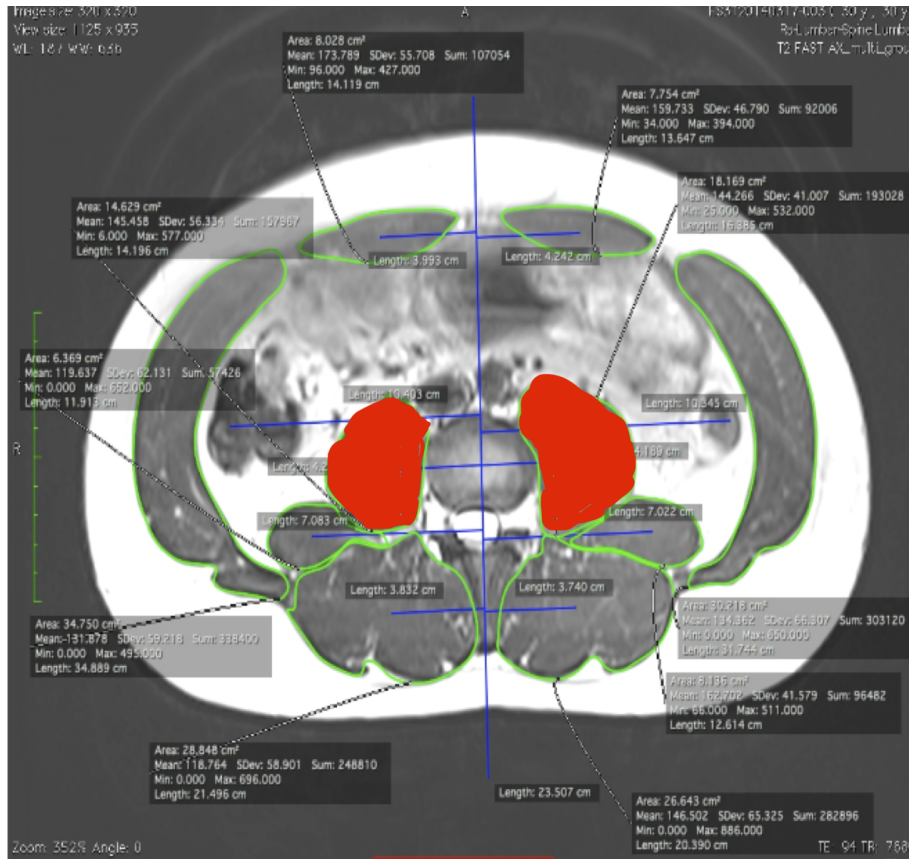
MRI Axial View of the Psoas Muscles
